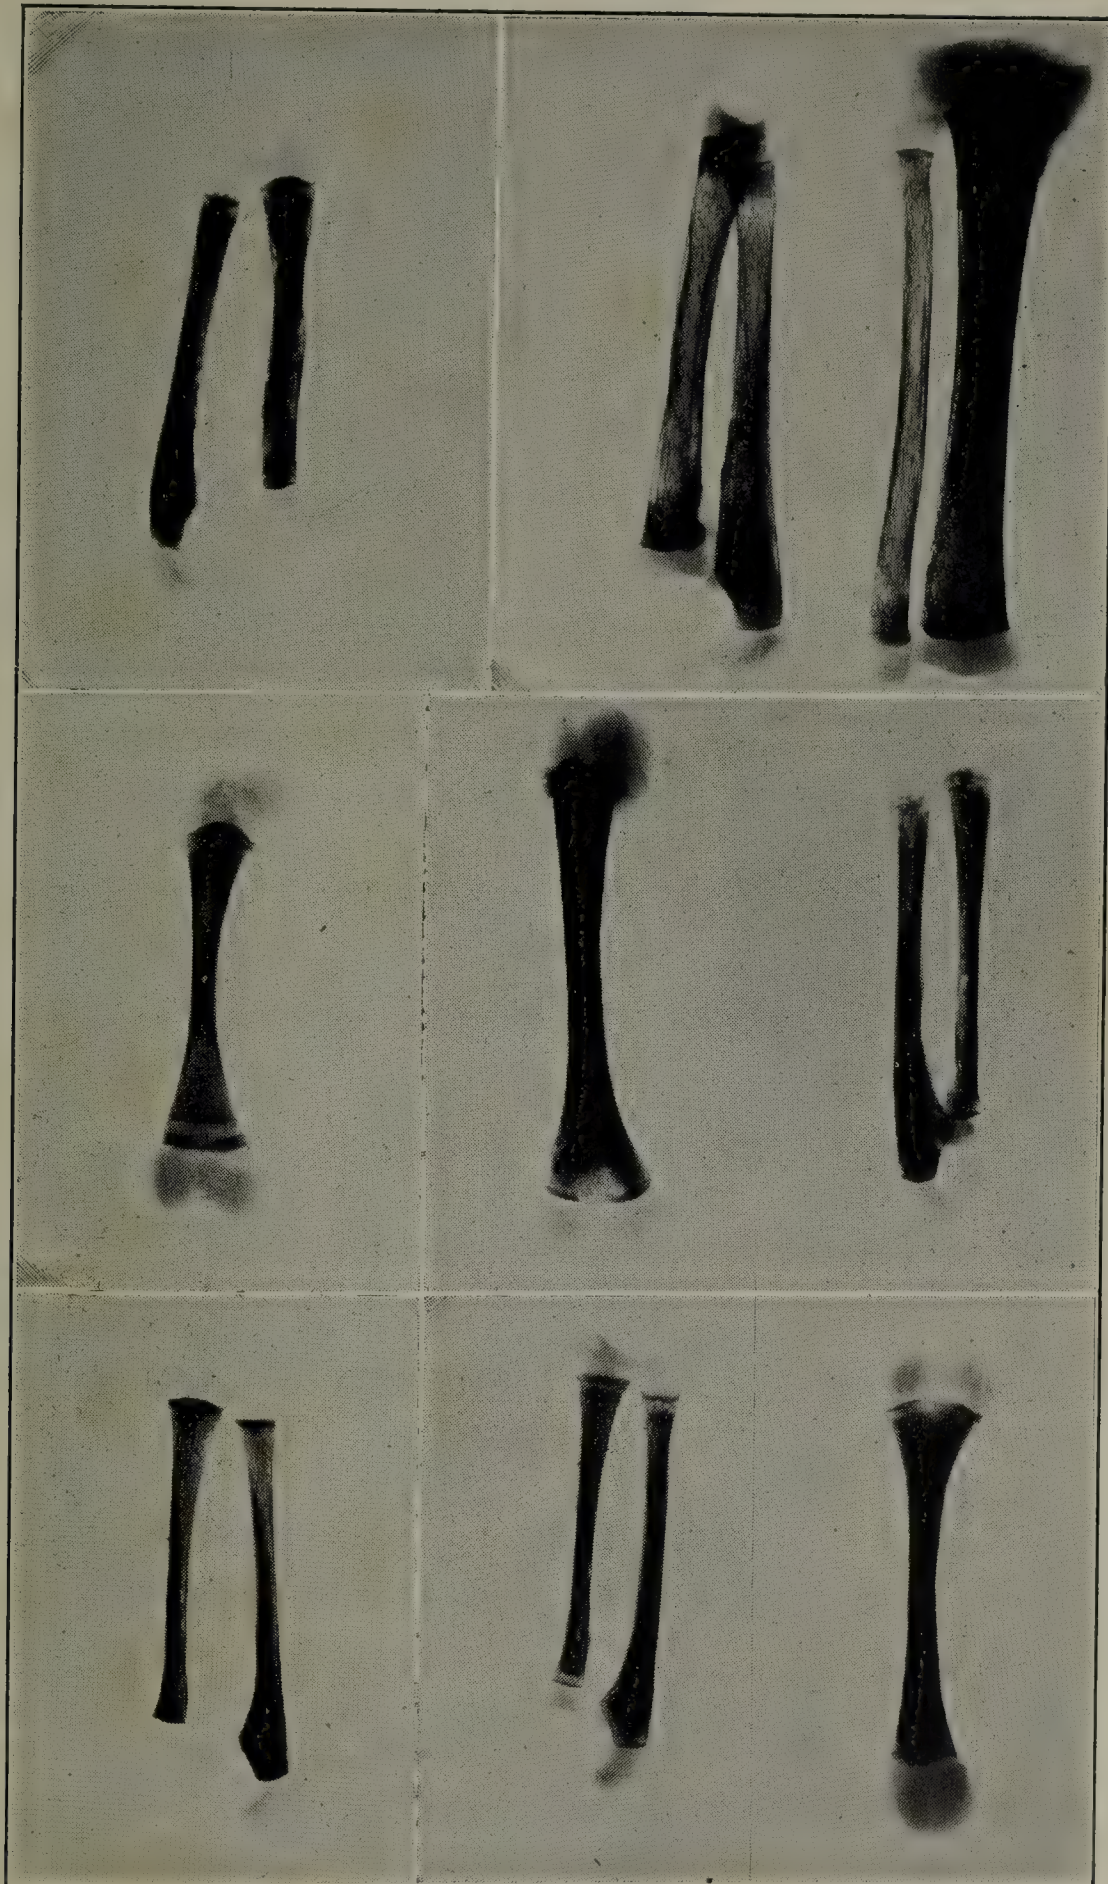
ROENTGENOGRAPHIC CHANGES IN THE LONG BONES IN EARLY CONGENITAL SYPHILIS.
